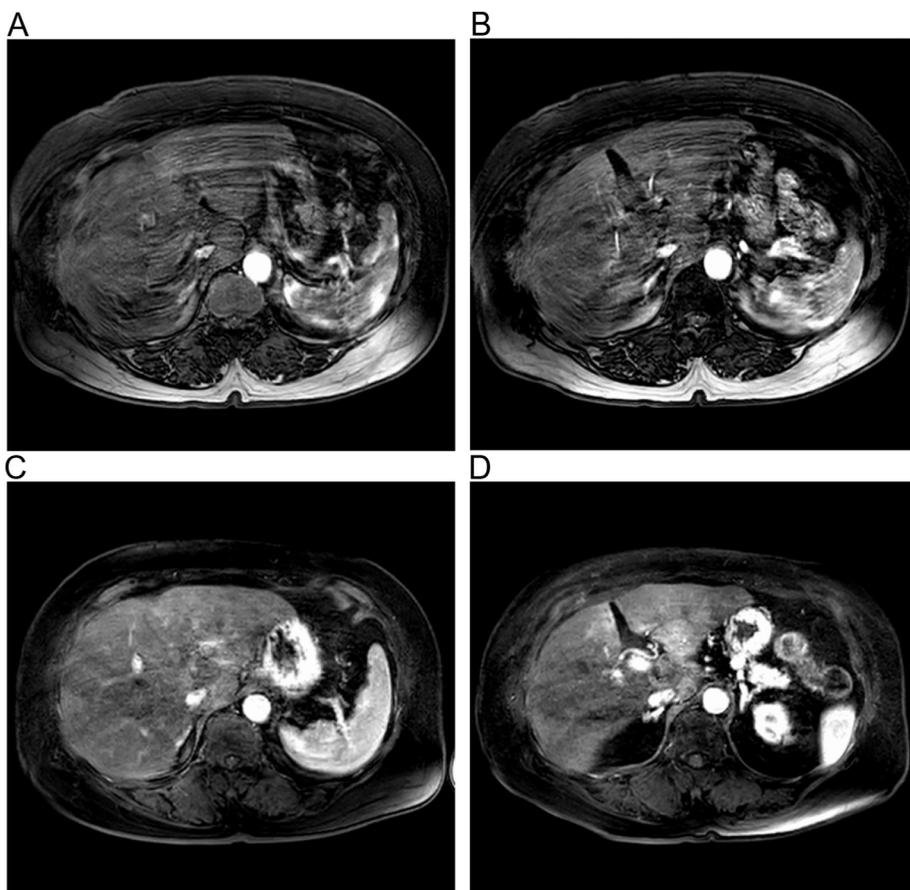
A 73-year-old female status post partial hepatectomy for hepatocellular carcinoma without viral hepatitis, who underwent gadoxetic acid-enhanced dynamic MR imaging with both eTHRIVE and CS-eTHRIVE technique at different times in the study period. Extensive motion artifacts were observed in hepatic arterial phase images (A, maximum parting plane; B, hepatic hilar level) with eTHRIVE (overall image quality scores of 1), whereas only mild artifacts were observed in those (C, maximum parting plane; D, hepatic hilar level) with CS-eTHRIVE (overall image quality scores of 3).
